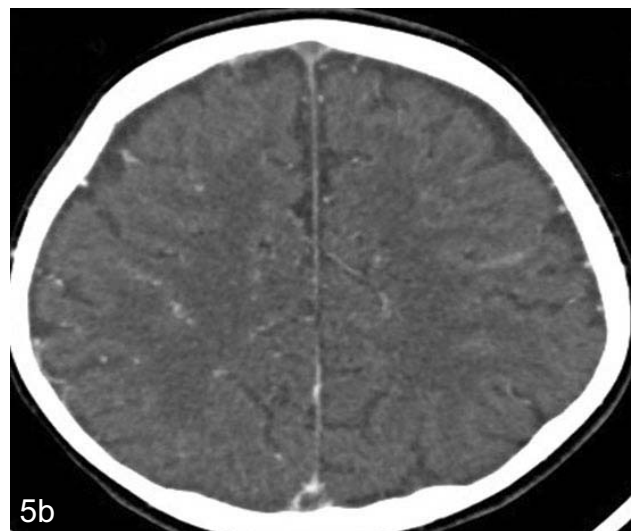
Showing hyperdense dural sinuses on a non contrast CT head. 5b: Showing Empty delta sign on post contrast CT head representing DST.
